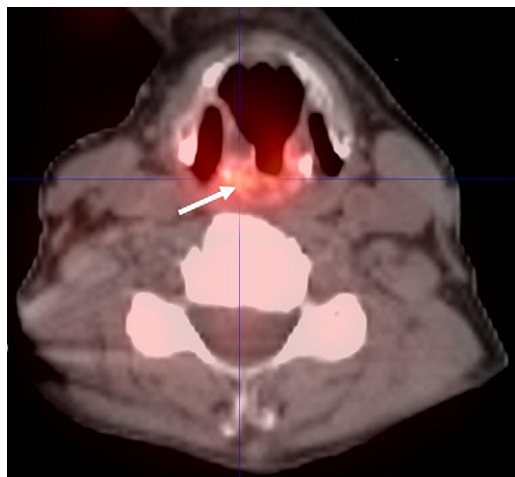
Physiologic uptake of FDG by the arytenoid musculature (arrow).
